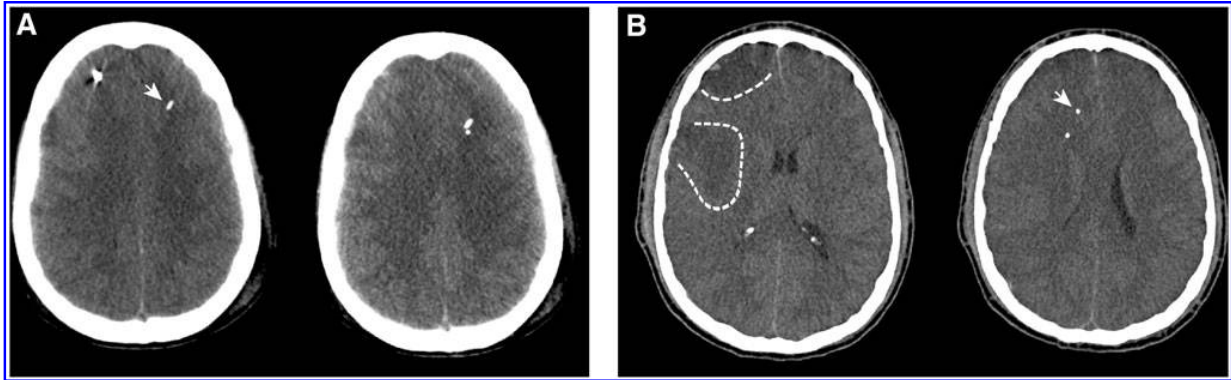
Images showing the different definitions used in this study for normal injured brain and traumatic penumbra. (A) Normal injured brain. This 18-year-old female was admitted to our institution (Vall d'Hebron University Hospital) 1 h after sustaining a severe TBI in a traffic accident. The Glasgow Coma Score (GCS) upon admission was 6 (1-5-T). The admission CT scan indicated findings compatible with a diffuse brain injury type III of Marshall's classification (right hemispheric swelling). In the slice shown on the left, the intraparenchymal intracranial pressure (ICP) probe is seen in the right frontal lobe. In the right slice (left hemisphere), both the oxygen partial pressure (PtiO₂) (white arrow) and the tip of the cerebral microdialysis (MD) probe are implanted in the macroscopically normal brain. (B) Traumatic penumbra (TP). This 22-year-old male was admitted to our institution 0.5 h after sustaining a severe TBI in an 8 m fall. GCS at admission was 6 (1-5-T). The CT scan was classified as a diffuse injury type III. In the right slice, both the PtiO₂ (white arrow) and the tip of the cerebral MD probe are placed in the apparently normal brain. However, the slice on the left taken 7 mm below the previous slice showed two frontal hypodense contusions (dashed outline). Because the probes were <20 mm away from the contusions, both were considered to be placed in a zone of TP.
